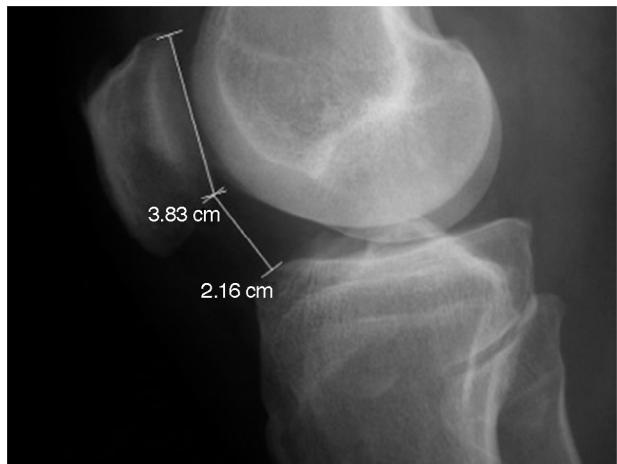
Lateral-view radiograph of the knee. Caton-Deschamps calculation.
